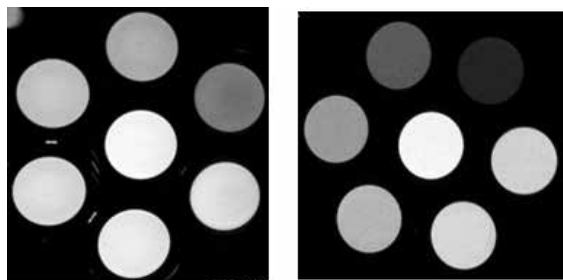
T2-weighted imaging of LNCaP cells (3×10^6) after 2h incubation with SPIO-C595 nanoprobe (Left) and DU145 (Right) at Fe concentration of 0, 5, 10, 20, 40, 80 $\mu\text{g/ml}$ (The vial in the middle is PBS alone without any contrast agent).
